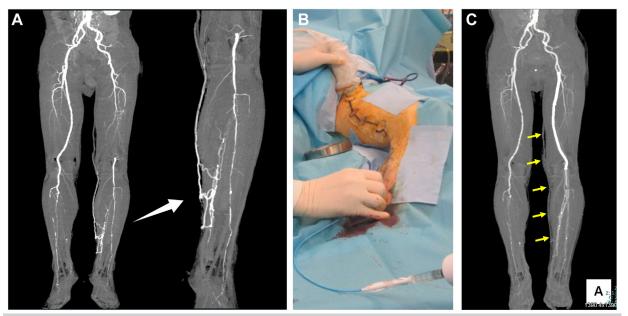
Patient 1. A, Preoperative contrast-enhanced computed tomography (CT) scan showing a long obstructive lesion from the left superficial femoral artery to the popliteal artery and arteriovenous fistulas (AVFs) between the left peroneal artery and great saphenous vein (GSV). B, Full-length occlusion of the left GSV using cyanoacrylate closure (CAC). C, Postoperative contrast-enhanced CT scan showing reconstruction of the left superficial femoral artery and occlusion of the left GSV (*arrow*) and most AVFs.
